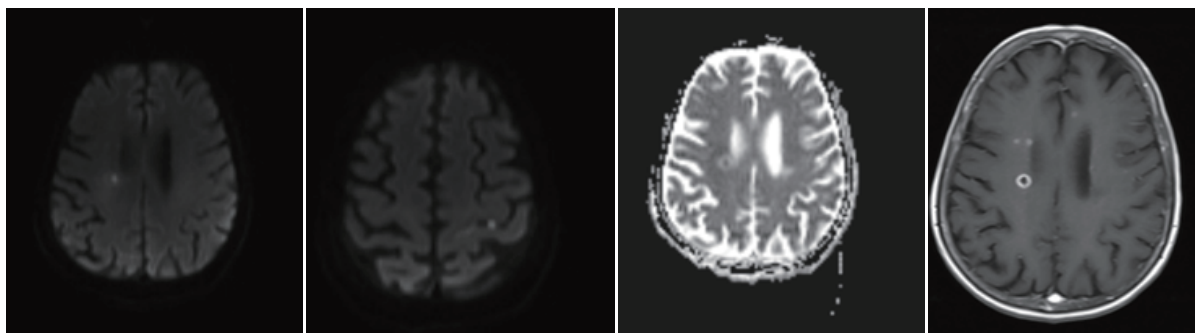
Contrast MRI and MRI diffusion images of the brain of Case 2
